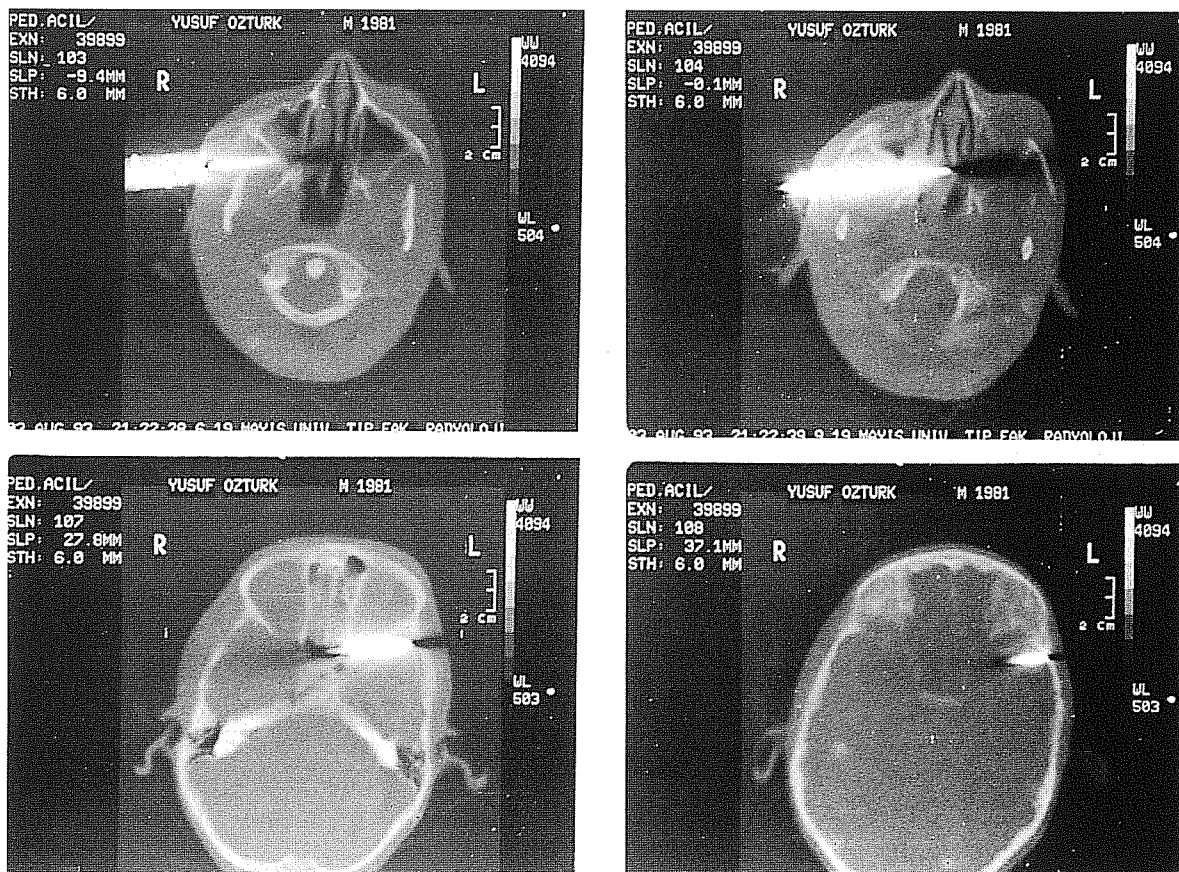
Postoperative axial CT of the faciocranial stab wound
